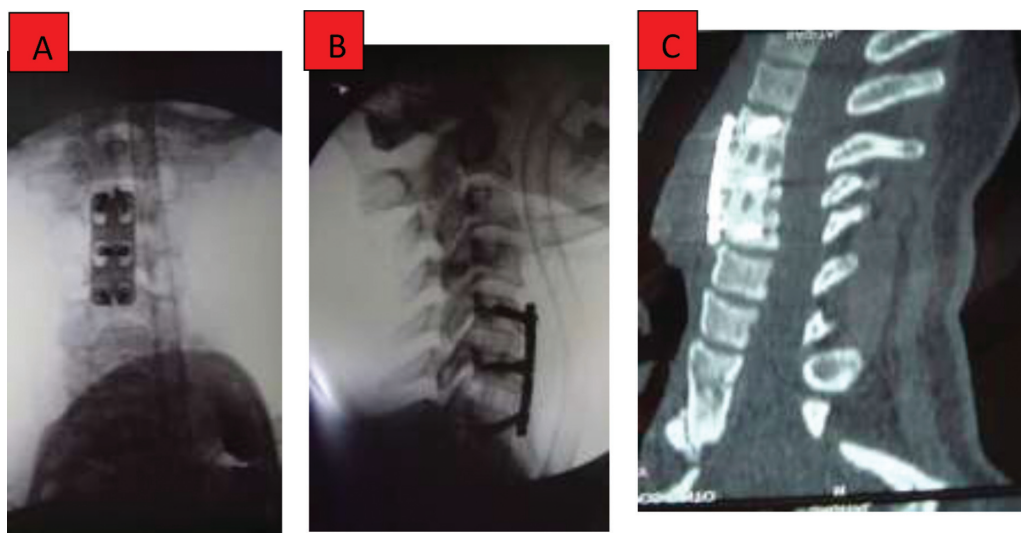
Anterior cervical arthrodesis with plate and cage in polyetheretherketone. (A) Intraoperative imaging in anteroposterior incidence; (B) Intraoperative profile image; (C) Computed tomography showing consolidation.
